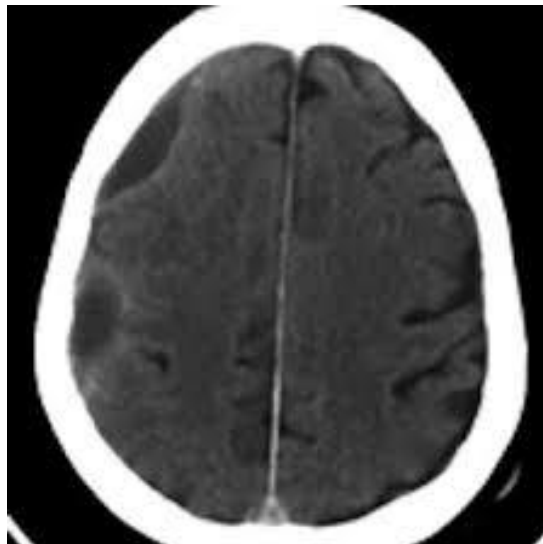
CT Brain Demonstrating Hypodense Lesion , Crescent Shaped At Right FrontoParietal Region.
